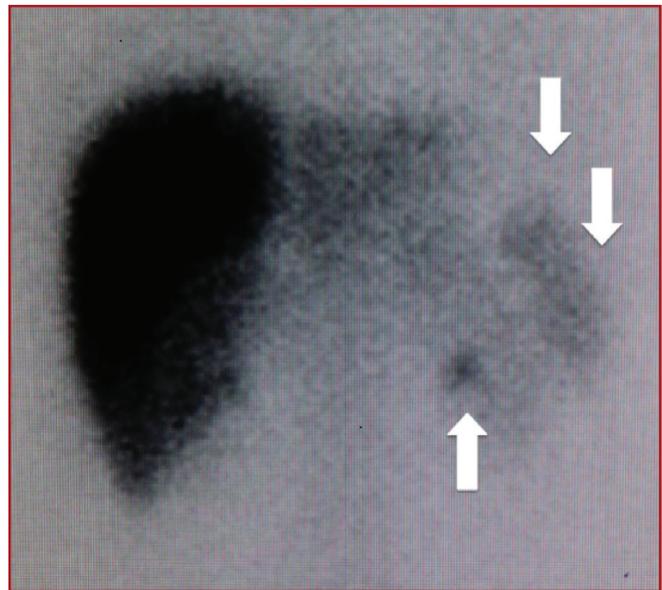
Tc-99m sulfur colloid scintigraphy in a 21-year-old man who had a history of post-traumatic splenectomy. Spleen is not visible due to splenectomy. Multiple conglomerated lesions of uptake in the left upper quadrant are seen (arrows).
